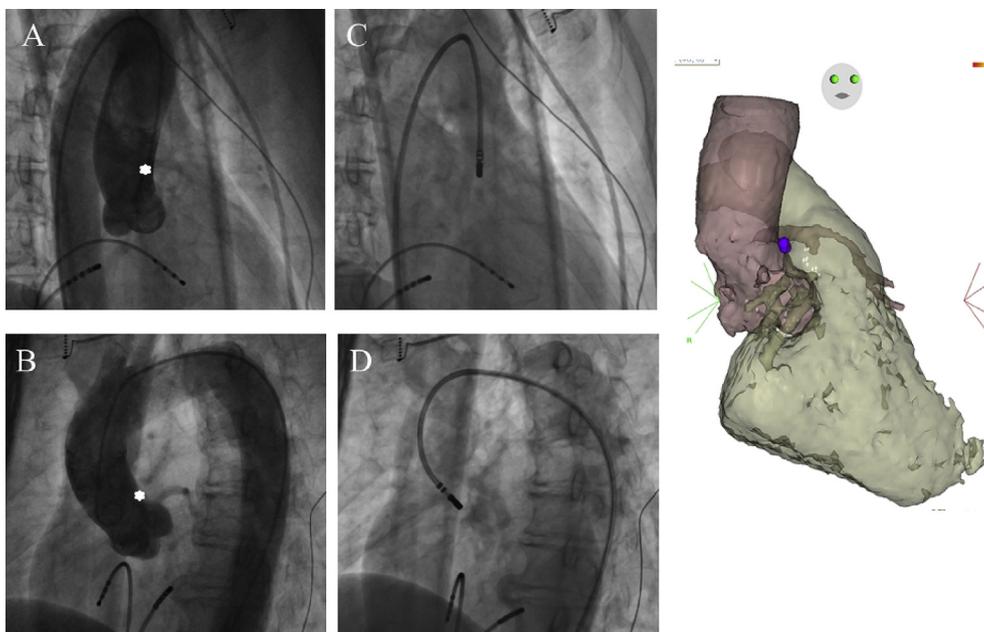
A and B. Ascending aortography in the right (A) and left (B) anterior oblique fluoroscopic projections, showing the successful ablation site (asterisk). C and D. Right and left anterior oblique fluoroscopic projections showing the catheter position at the successful ablation site. E. 3-dimensional antero-posterior computed tomographic image integrated into the CARTO mapping system showing the site of successful ablation (purple tag).
